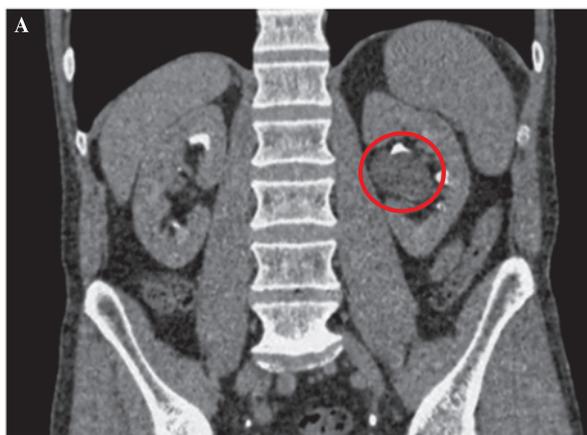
Patient Sh, 64 years old. Contrast-enhanced CT (A: sagittal section and B: coronal section): lesion of size 36 mm and density of 7.2 HU. Parapelvic cyst (with a suspicion of pelvis tumor) before transurethral marsupialization
